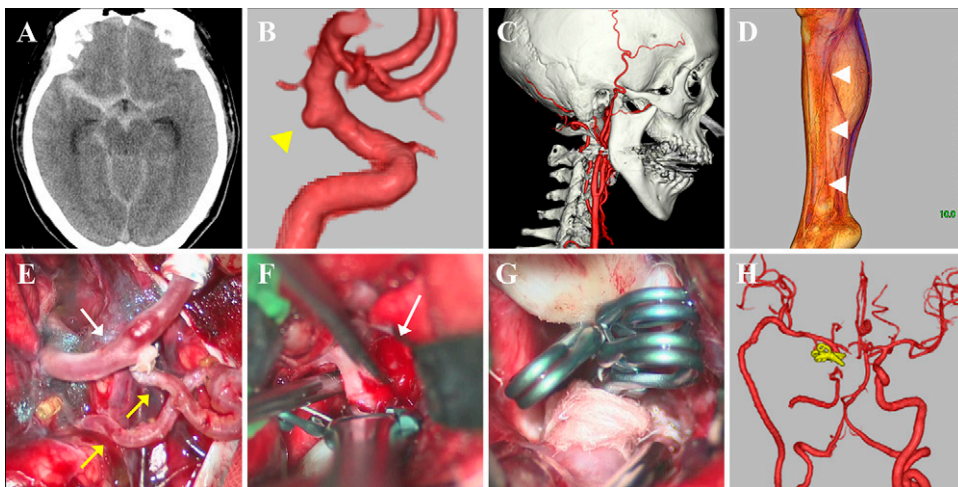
A: Initial CT images of the head revealed a diffuse SAH. B: 3D CT angiography revealed an aneurysm (arrowhead) on the posterior wall of the right ICA, located on the distal side of the ophthalmic artery. C: Both the frontal and parietal branches of the STA were well developed. D: Preoperative nonenhanced 3D CT venography demonstrated an appropriate saphenous vein (arrowheads) for the bypass graft. E: The STA-M4 double bypass (yellow arrow) and the ECA-saphenous vein-M2 bypass (white arrow) were established followed by trapping of the aneurysm. F: The intraoperative view shows the BBA (white arrow) of the right ICA. G: The aneurysm was trapped while preserving the origin of the PCOM artery. H: Postoperative 3D CT angiography showed no recurrence of the BBA and patency of the high-flow bypass.
